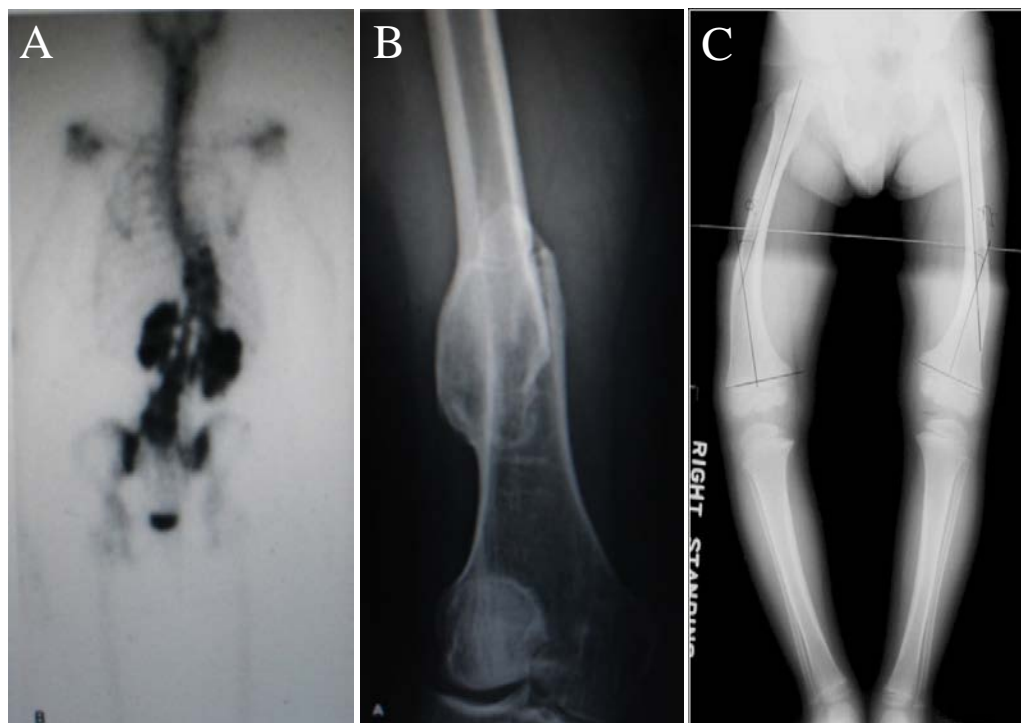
Bone phenotypes of Hyper IgE Syndrome (HIES). A: bone X-ray scan demonstrated spinal scoliosis; B: healed pathologic distal femoral fracture in a HIES patient; C: a 3 year 9 month old patient with HIES showing bowing of the legs.
